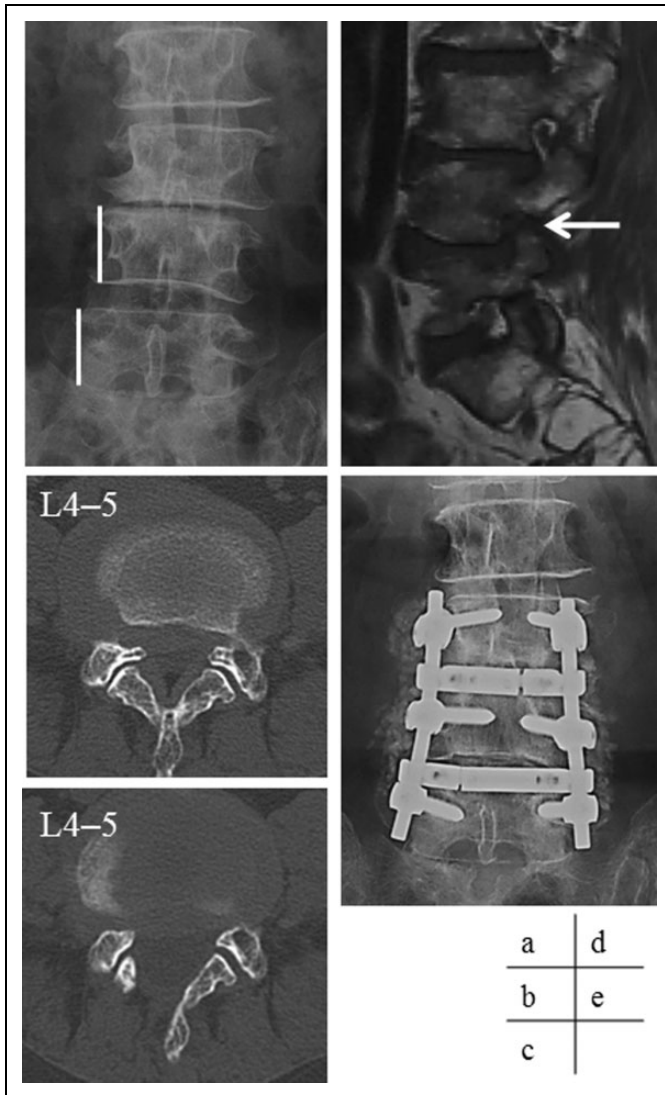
Representative case: A 68-year-old woman with L4-5 lumbar lateral listhesis and scoliotic disc wedging reported intermittent claudication owing to sciatica. We performed L4-5 MBDU. After this MBDU, her sciatica disappeared, but anterior thigh pain appeared 1 month postoperatively. We diagnosed radicular pain secondary to L4-5 right side intraforaminal stenosis. We therefore performed a fusion operation 5 months after the initial operation. Nevertheless, the patient's severe leg pain and low back pain persisted. (a) Preoperative radiographs of the lumbar spine. (b) Preoperative computed tomography imaging at L4-5. (c) Postoperative computed tomography imaging at L4-5. (d) Sagittal T1-weighted magnetic resonance imaging of the right foramen at L4-5 (arrow indicates foraminal stenosis). (e) Anteroposterior view radiographs of the lumbar spine at final follow-up.
